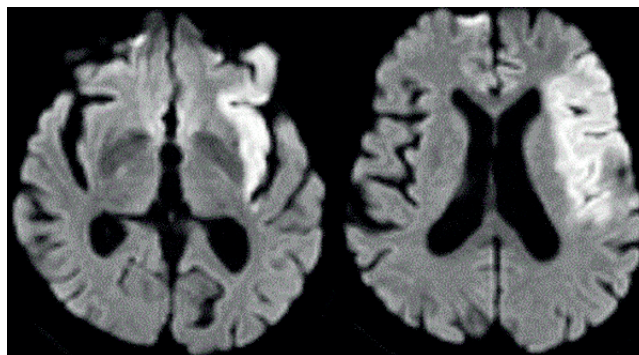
Brain diffusion-weighted magnetic resonance imaging, involving left insular cortex.
